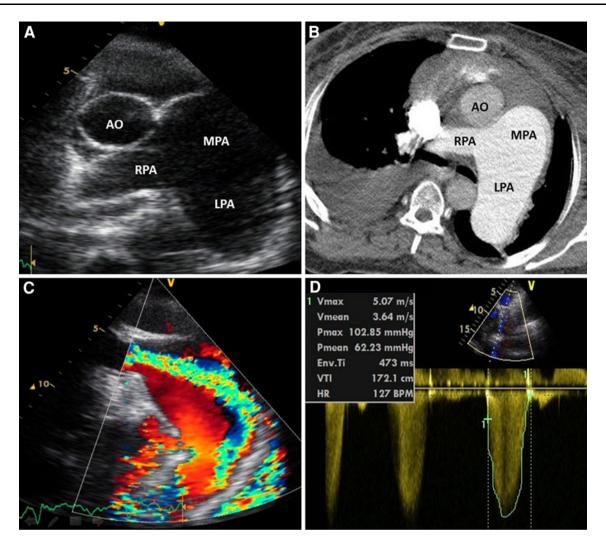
a Transthoracic echocardiography showing a pulmonary artery aneurysm. b Thorax computed tomography showing a pulmonary artery aneurysm. c Color Doppler echocardiography
